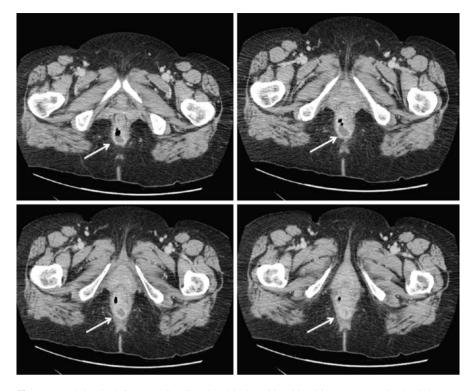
Abdominal CT scan. Small perianal lesion $(32 \times 30 \times 28 \text{ mm approx})$ in the right posterior–lateral wall with hyperemic wall and partial gas content, probably an abscess (arrows). Not free fluid in the pelvis
